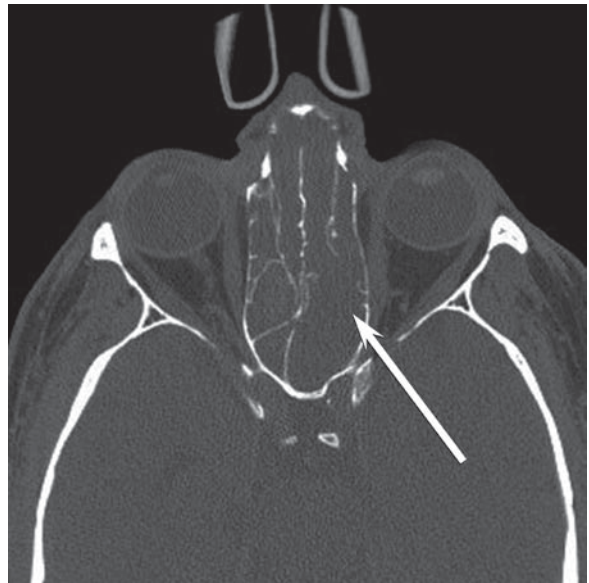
Remodeling of the ethmoid septa. Axial CT of a patient with NP shows thinning of the posterior ethmoid septa (*arrow*) so that they are no longer visible on CT. This is still a benign pattern
